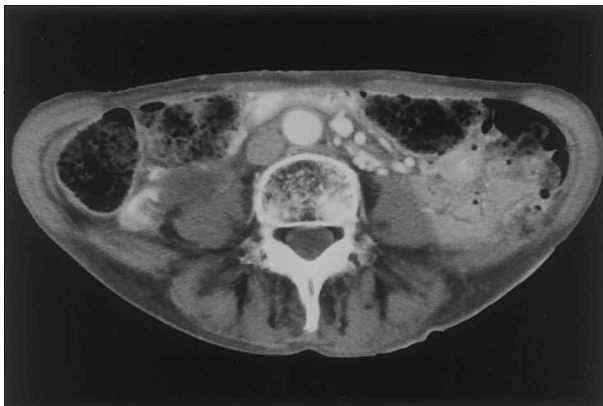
Follow-up CT scan at 6 years after the treatment. The tumor, markedly decreased, is a small low-density structure 20 mm in diameter.
